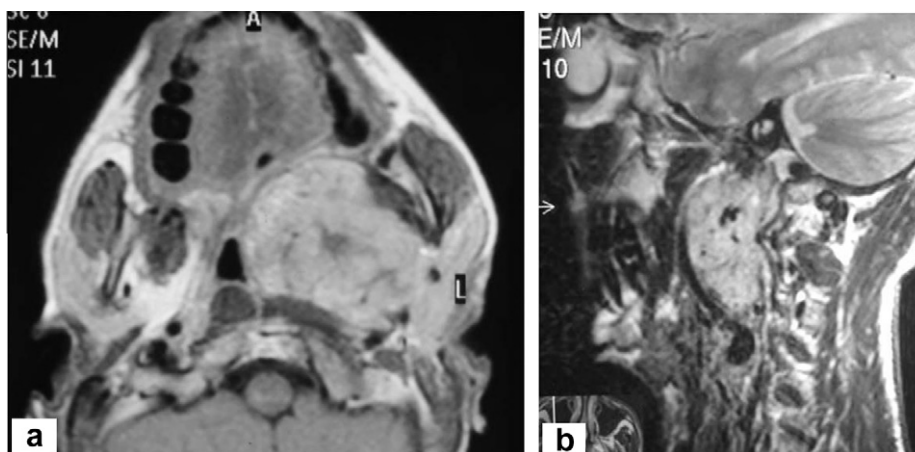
MRI of the patients with: (a) pleomorphic adenoma arising from the deep lobe of the parotid gland; (b) vagal paraganglioma of the superior aspect of the PPS with anterior displacement of the internal carotid artery.
